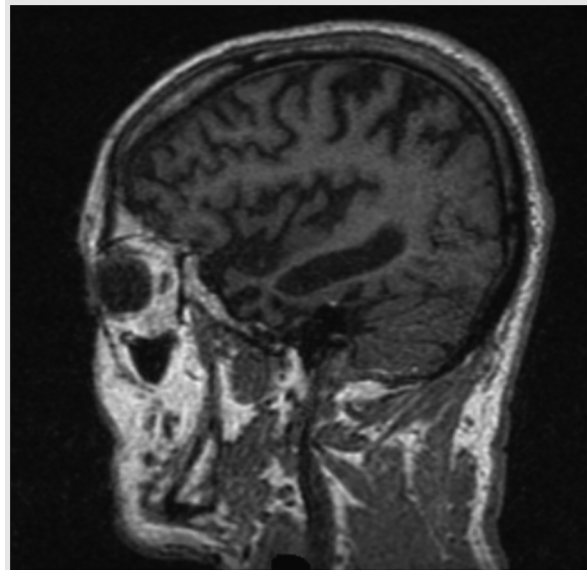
MRI sagittal T1-weighted image. Note the severe temporal lobe atrophy, which includes anterior, inferior, and lateral regions, relative to the rest of the brain.
